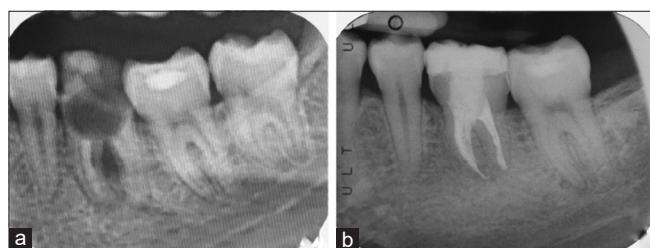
Periapical intraoral radiography before the surgery (a) and after 36 months of follow-up (b)
